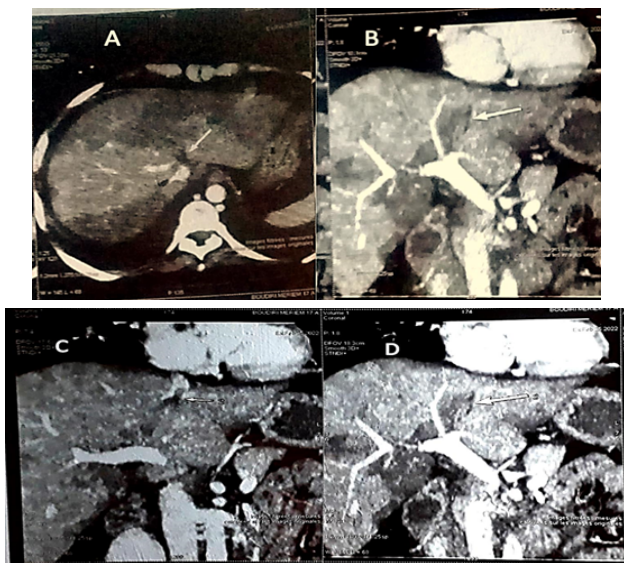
Abdominal CT angiography axial cut shows: Images A and B the arrow points to thrombosis of the left suprahepatic veins, with liver perfusion disorder without hepatic dysmorphism. Abdominal CT angiography: Images C and D the arrow points to thrombosis of the left-right suprahepatic veins with hepatic perfusion disorder.
